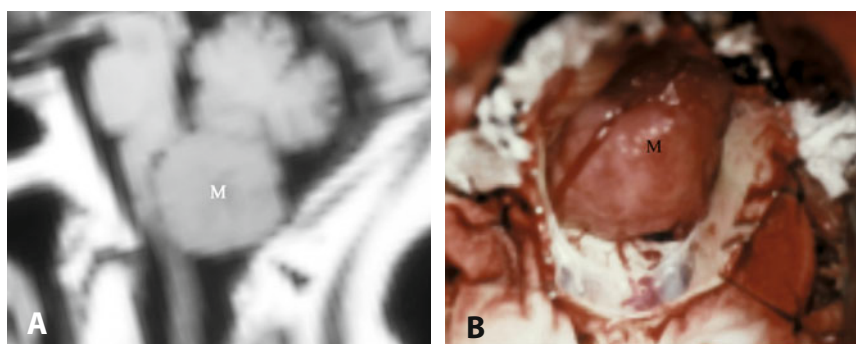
Lateral meningioma inserted above the VA on coronal T1-weighted MRI with gadolinium. The lesion is developed above the VA. M: meningioma. VA: vertebral artery.
